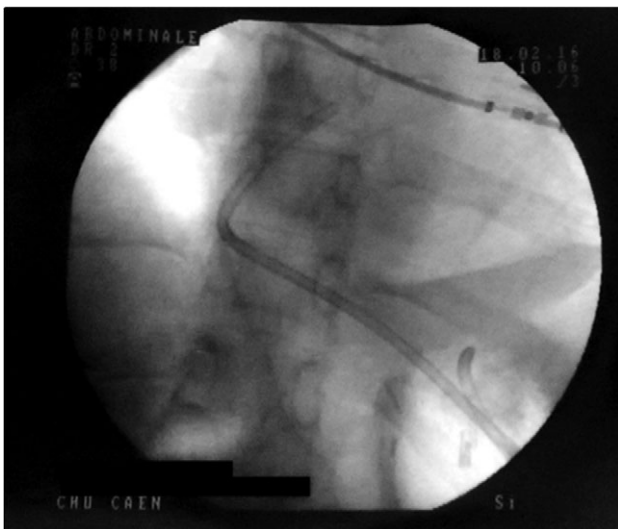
Control X-ray after the double pigtailed drain has been put up.
